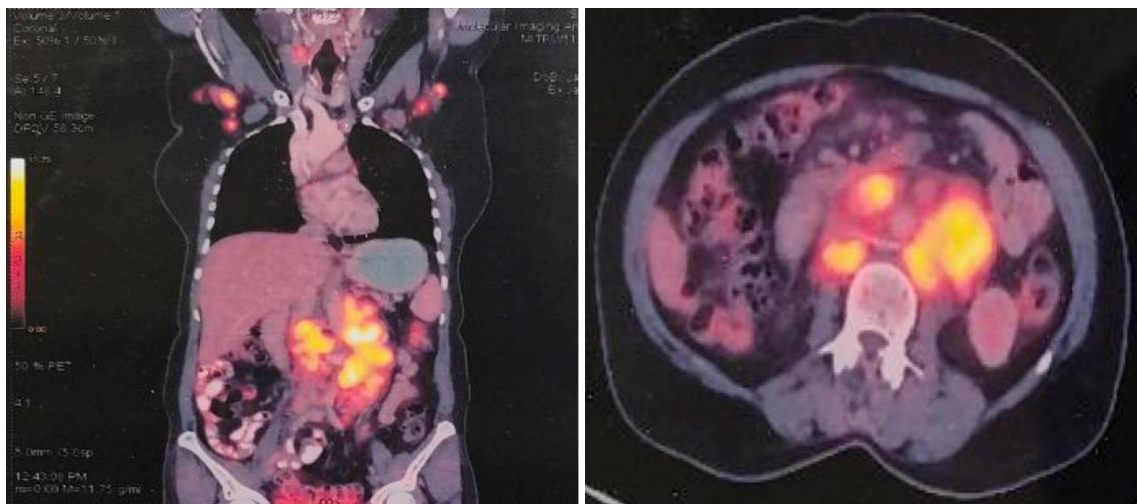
18 FDG – PET CT scan- FDG avid lymphadenopathy on both sides of the diaphragm with no abnormal uptake in the liver, spleen, pancreas, kidneys or adrenal glands.
